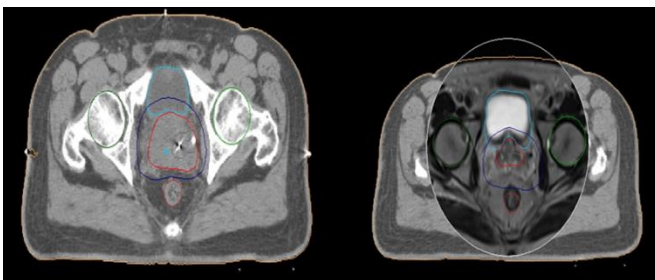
MRI scans overlying a CT scan showing differences in targets and OARs definitions
